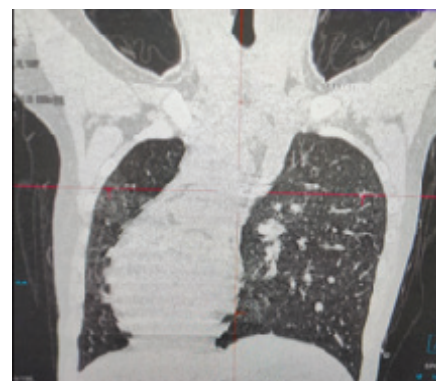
Computed tomography of the chest. Dextrocardia (right-sided, right-formed heart)
